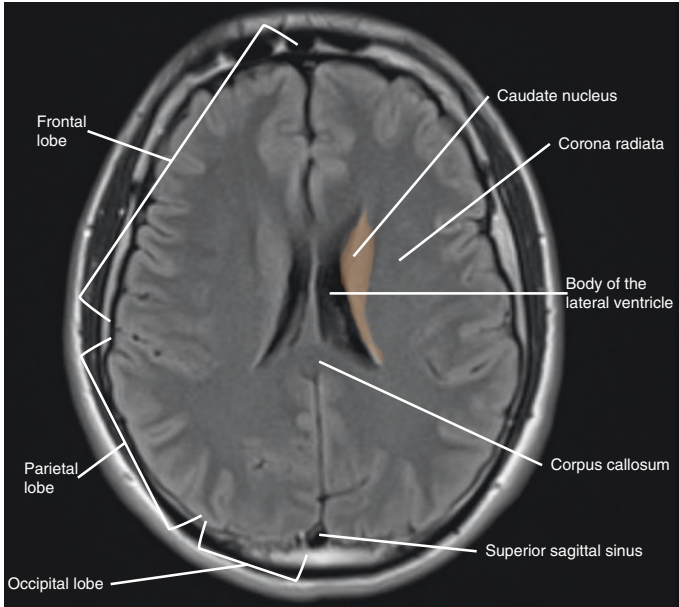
Cerebrum (Flair sequence MRI brain)
